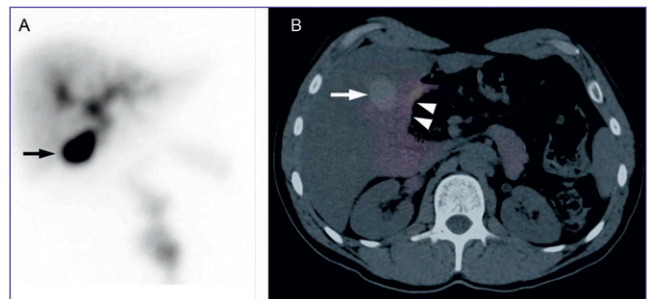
(A) Planar hepatobiliary iminodiacetic acid image was uncertain, thought likely to be gallbladder filling. (B) SPECT/CT localized activity to the duodenum. There was no gallbladder filling.
